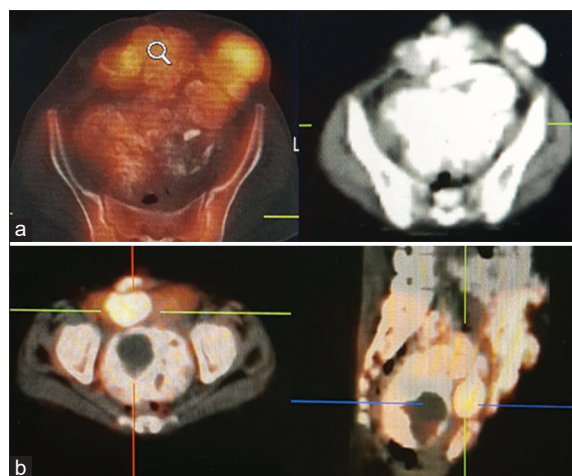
(a and b) Single-photon emission tomography/computed tomography showing tracer accumulation associated with peritoneal and abdominal wall calcified masses
